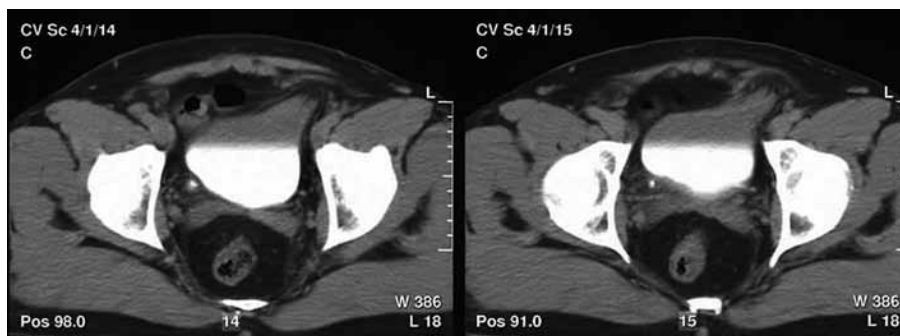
Pelvic CT scan demonstrates the left upper part of the bladder herniated into the inguinal canal. There is no contrast media in the herniated part of the bladder. Inguinal canal does not contain bowel.
